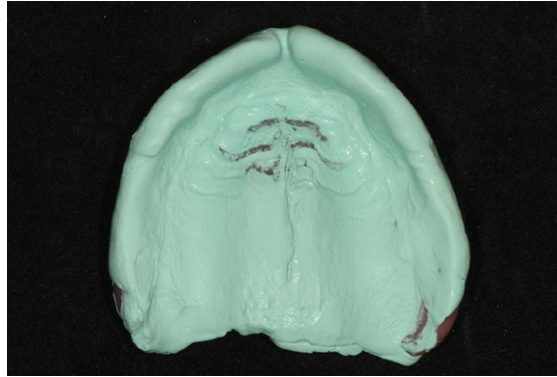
Radiopaque PVS placed prior to making a CBCT allowing the software to recognize the soft tissue profile.
